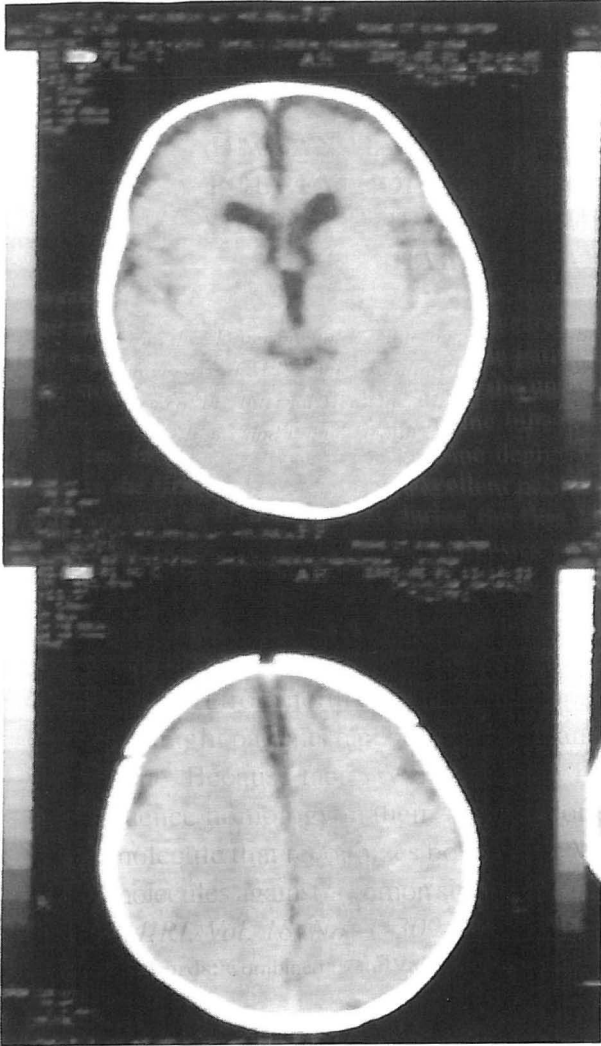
The follow-up CT scan 2 months later does not define the white matter involvement, but demonstrates progressive mild diffuse volume loss.
